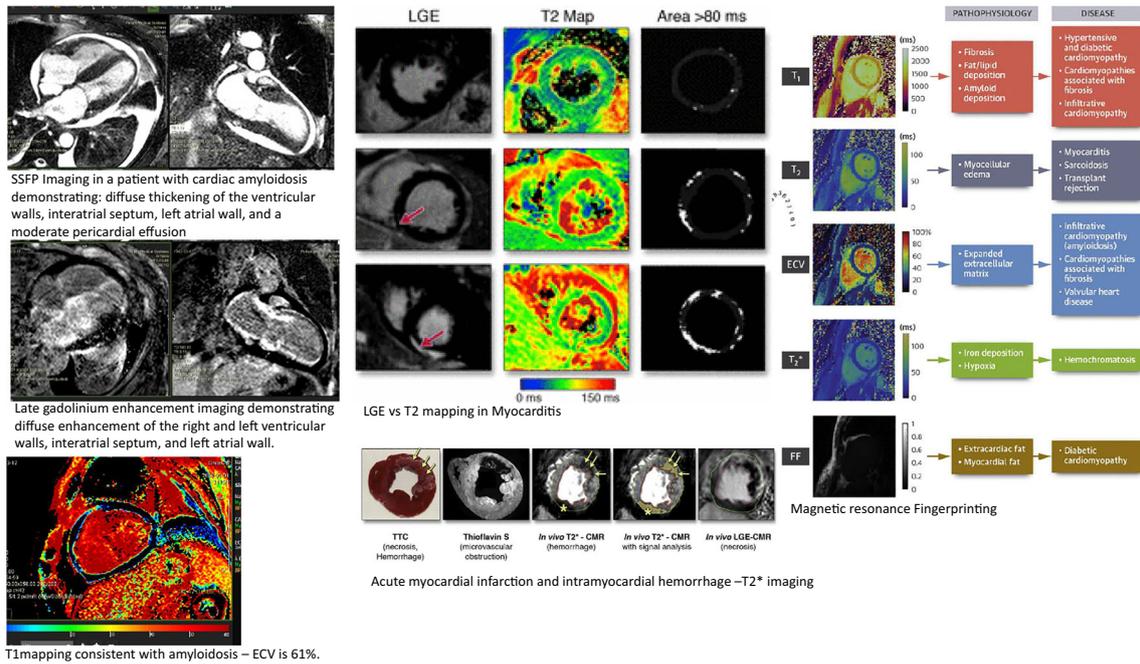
Tissue characterization with Cardiac MRI.
